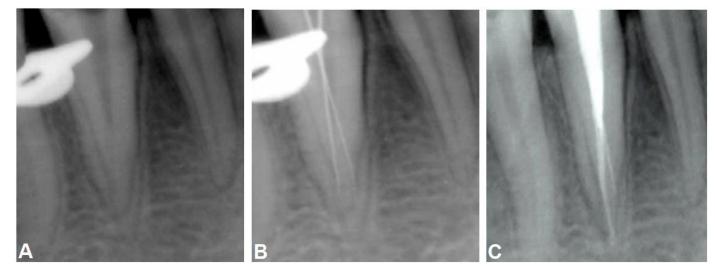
Radiographs of tooth 43. A) Preoperative radiograph, B) Working length radiograph, and C) Post obturation radiograph
